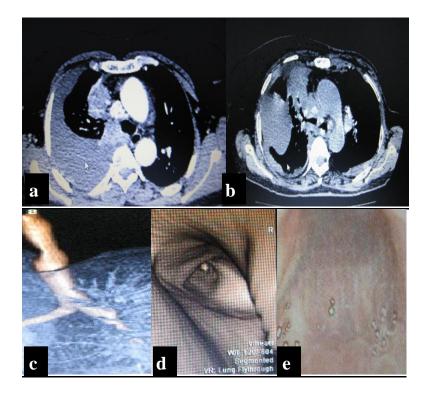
<sup>£</sup>: Metastatic Br. Ca tracheo-bron. invasion & external compression (a&b) Axial CT images shows multiple medias. Soft tissue masses encroaching upon & invading the trachea and Rt. Main bronchus. (c) "D image showed circumferential tracheal narrowing due to mass effect & attenuated Rt. main bronchus (d) VB CT showed mildly narrowed trachea (e) FO broncoscopy showed congested mucosa, no masses.
